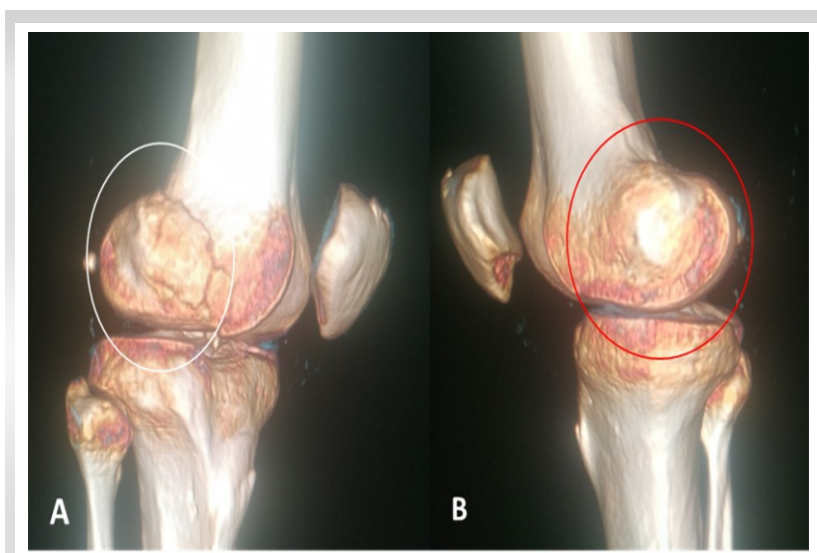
(a and b) 3d reformatted CT images with # lateral condyle indicated by a white circle and an intact medial condyle by a red circle.
